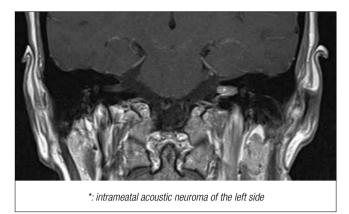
Coronal MRI (T1 sequence with contrast enhancement). Dpt. of Neuroradiology, University Hospital of Würzburg, Germany; Chair: Prof. Dr. M. Pham.
